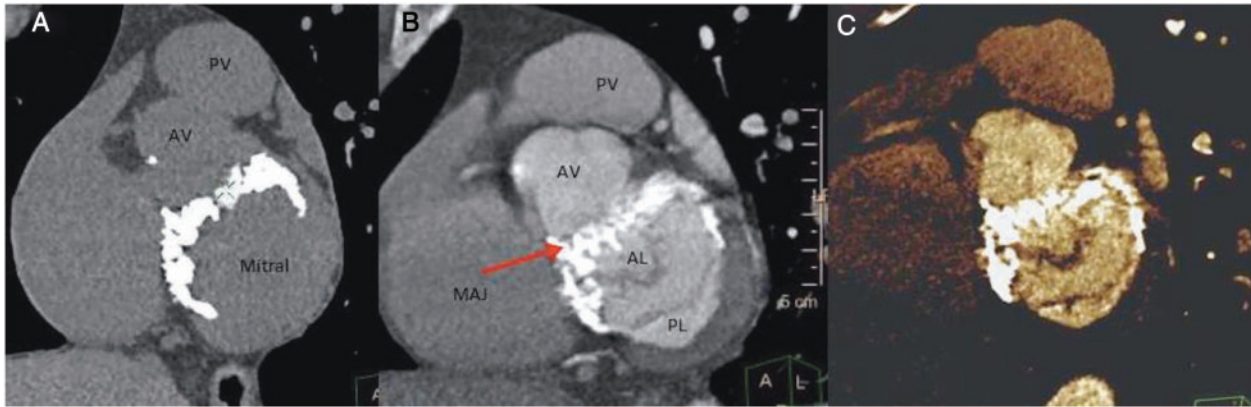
Multiplanar reconstruction of cardiac computed tomography scan. Short-axis view of the mitral annulus showing the mass calcification of the heart's fibrous skeleton, mitral annulus and the atrioventricular groove. (A) Non-contrast CT. (B) Gated contrast computed tomography. (C) Volume-rendered. AL, anterior mitral leaflet; AV, aortic valve; MAJ, mitro-aortic junction; PL, posterior mitral leaflet; PV, pulmonary valve.
